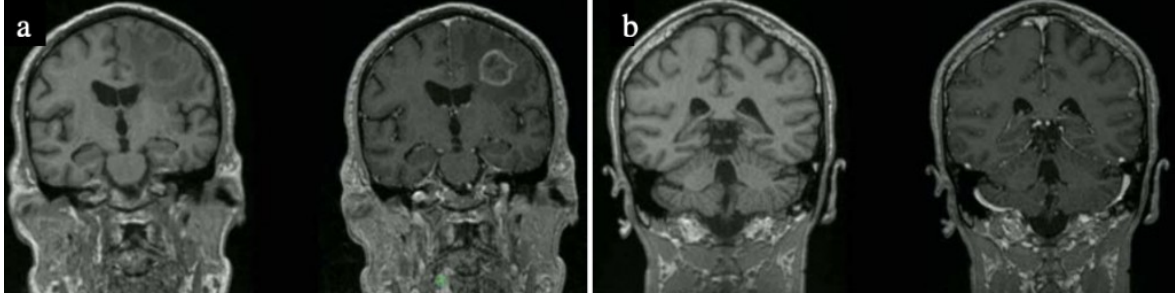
Glioblastoma (a) and metastasis (b) on coronal T_1 -weighted MRI before (left) and after (right) administration of gadolinium-based contrast agent (Gd-CA). Post-contrast enhancement delineates pathological regions that are poorly visible on pre-contrast images. Reproduced from [54].
